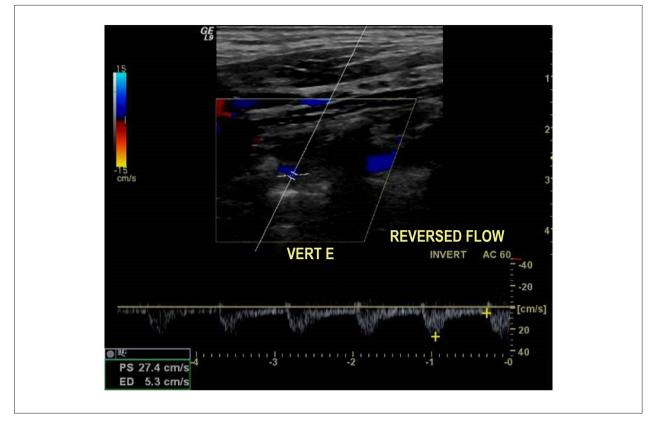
Spectral Doppler (PW) imaging of the left vertebral artery shows completely reversed flow, which is consistent with type 3 steal (complete).¹⁵
